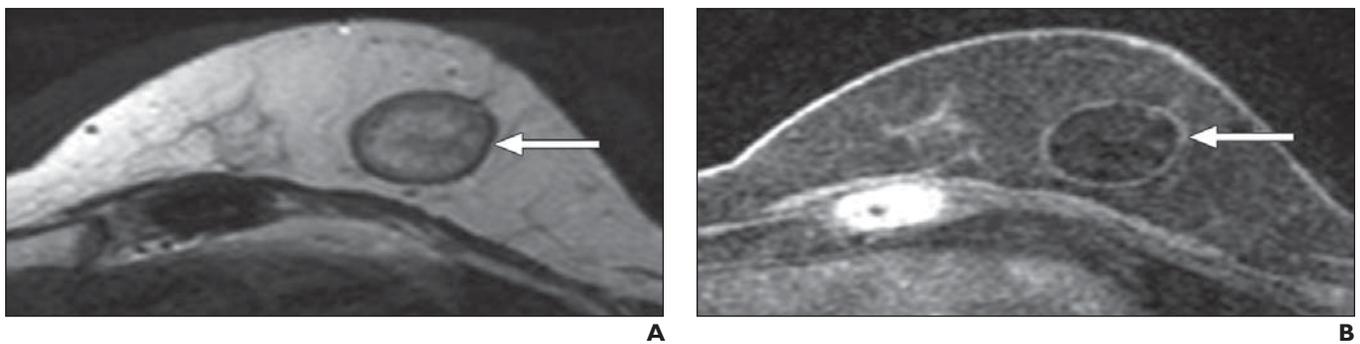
Myxomatous fibroadenoma in 54-year-old woman with history of breast cancer who had focal round mass with smooth margins detected on screening MRI. A, T2-weighted image shows round mass (*arrows*) with typical high signal intensity, which correlates with fluid-dense mucinous stroma. B and C, Unenhanced (B) and contrast-enhanced (C) images show homogeneous enhancement (*arrows*) and nonenhancing dark internal septations (*arrowhead*).
